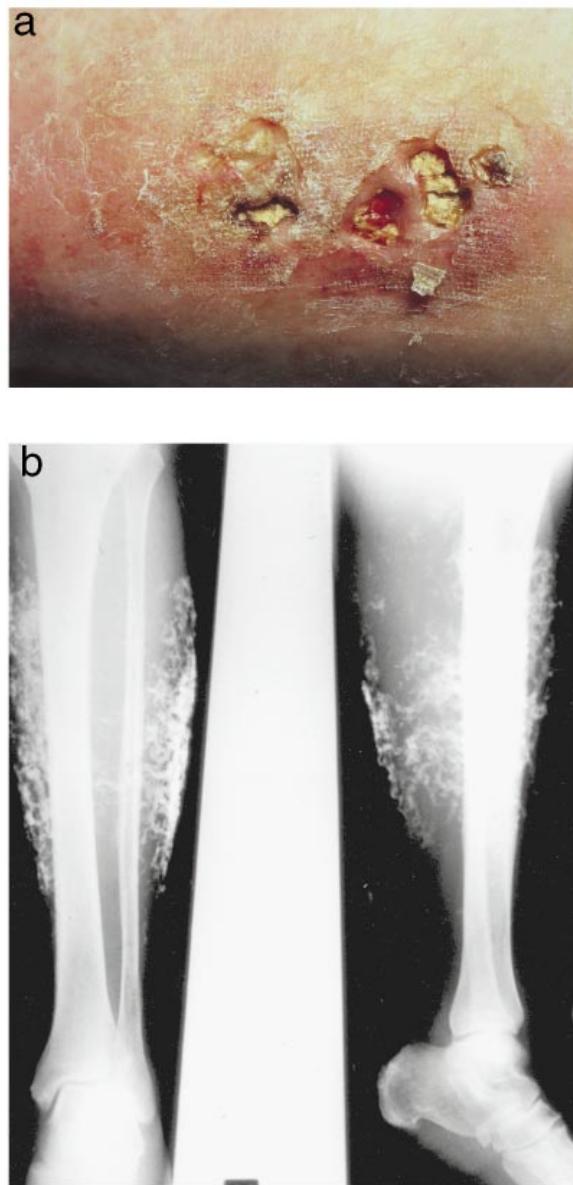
(a) Leg ulceration with visible extrusion of calcium. (b) X-ray of left leg showing extensive subcutaneous calcification.
